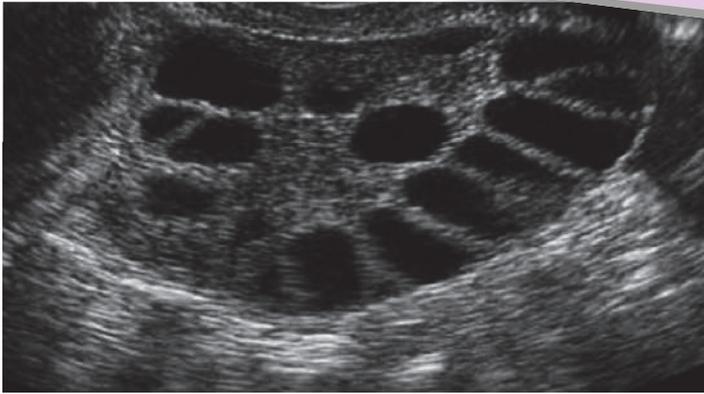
Typical sonographic appearance of a polycystic ovary with multiple peripheral follicles
